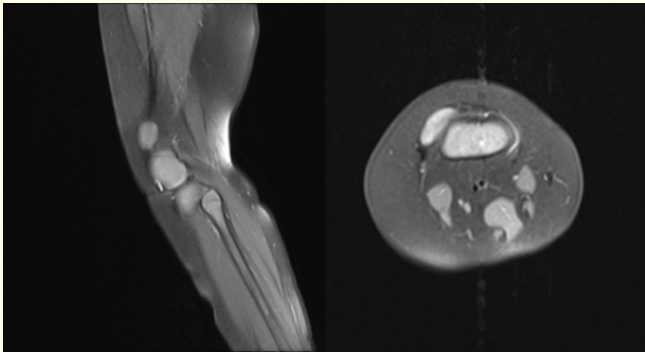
MRI image of the right knee showing the dislocation of the patella.
